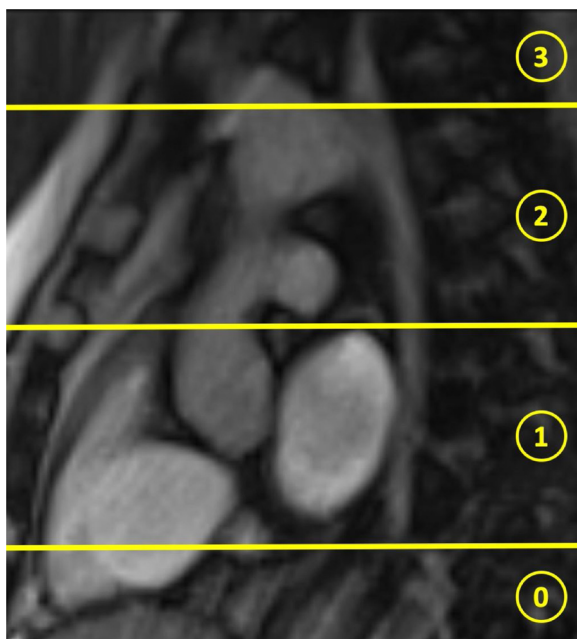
MRI reflux grading rated according to anatomical reflux height on a scale form 0–3. The esophagus was divided in 3 segments according to surrounding anatomical landmarks: the lower esophagus between the lower esophageal sphincter and the upper atrial margin (1); the middle esophagus between the upper atrial margin and the aortic arch (2); and the upper esophagus above the aortic arch (3). No visible reflux was graded as 0.
